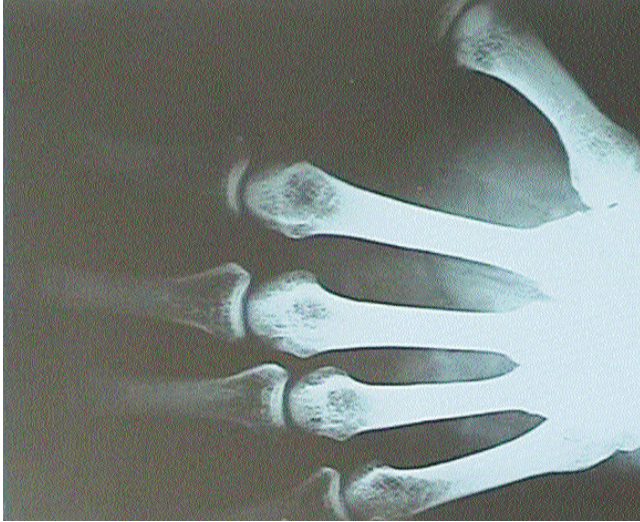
The first Xeroradiophotography of the inventor's hand has shown the more proper bone structure and edge sharpness, specifically around the carpo-metacarpal joints to compare with current radiograph of the same hand.
